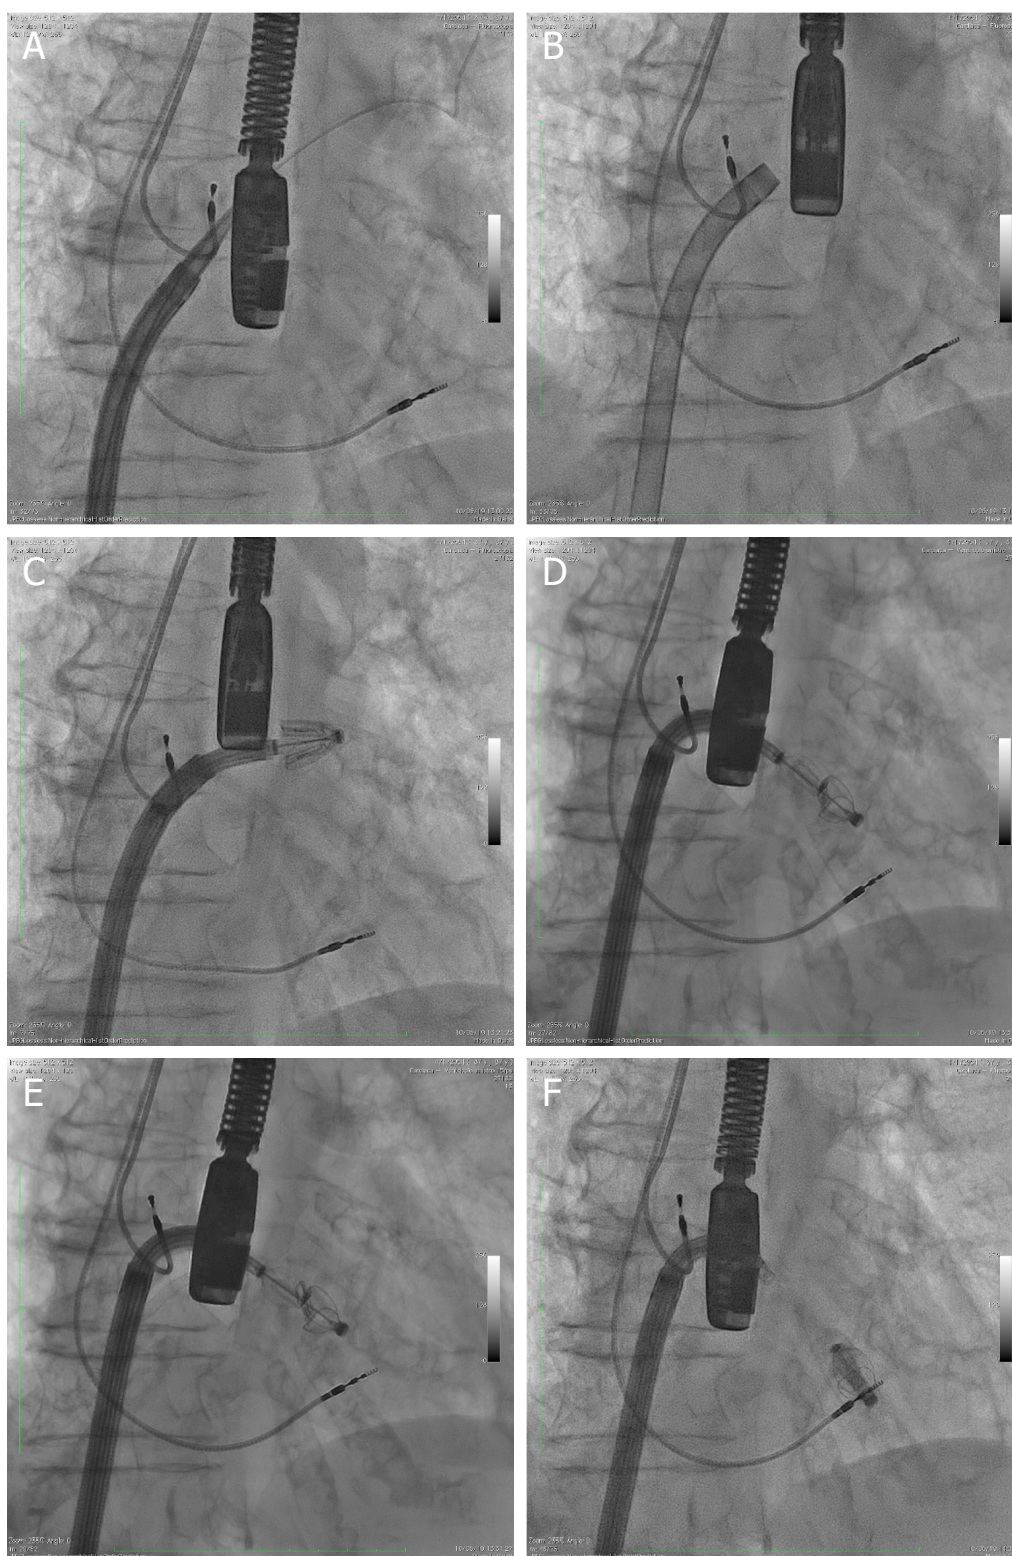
Procedural fluoroscopic steps for the implantation of the Edwards PASCAL transcatheter mitral valve repair system. With a transeptal approach, the steerable guide sheath and the steerable catheter were introduced into the left atrium while simultaneously flexing the implant catheter toward the mitral valve (A-C); the valve was crossed with the opened paddles achieving a straightforward positioning below the leaflets. After the three-dimensional transesophageal echocardiography guided orthogonal alignment to the coaptation mitral line, the implant was retracted until leaflets were grasped simultaneously (D, E); when sufficient and straight leaflet insertion was confirmed, the clamps were dropped, and device was closed. Immediately after, the residual mitral regurgitation and transvalvular gradient were systematically assessed to confirm optimal mitral regurgitation reduction before final deployment (F)
